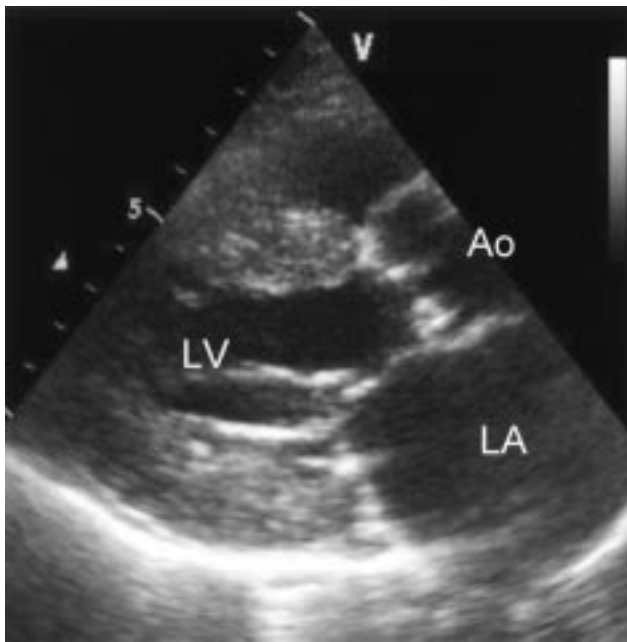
Preoperative echocardiogram revealing aortic valve stenosis with severe calcification.
